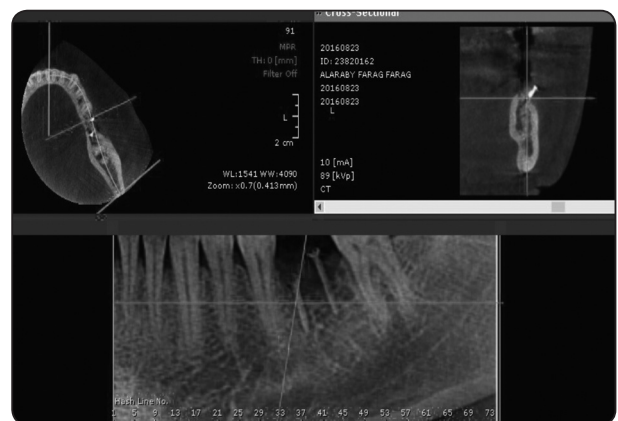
Cone Beam CT and measurements on Ondemand 3D software
